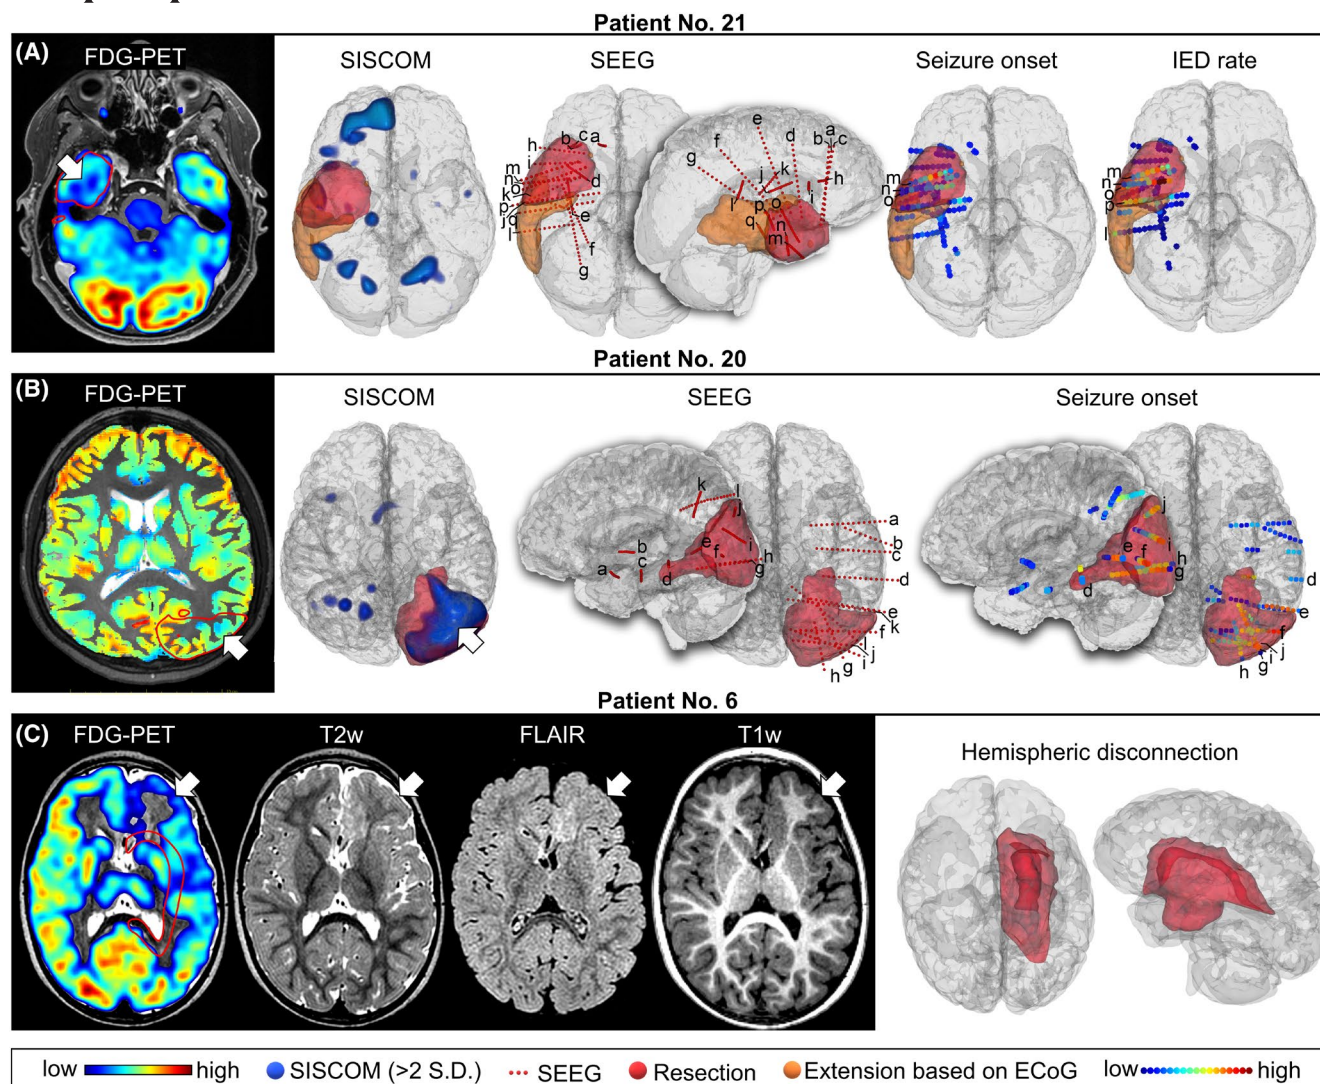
An example of the importance of multimodal assessment in three postoperative seizure-free patients. (A) Patient 21 had normal magnetic resonance imaging (MRI) findings and lateralizing but nonlocalizing single photon emission computed tomography coregistered to MRI (SISCOM). Scalp electroencephalography (EEG) showed extensive frontotemporal epileptiform activity on the right. Fluorodeoxyglucose positron emission tomography (FDG-PET) with additional postprocessing revealed a mild hypometabolism on the base of the temporal pole (arrow), which was the target of stereoelectroencephalographic (SEEG) exploration of frontal (a–c, j, k), insular (d–i), temporal (m–q) lobes, and Rolandic operculum (l). Seizure onset zones⁴¹ were confirmed in the hypometabolic tissue. However, interictal epileptiform discharges (IEDs) were widespread in the temporal lobe, indicating an extensive epileptic network⁴². The initial resection plan (red area) was extended intraoperatively on the basis of electrocorticography (ECoG; orange area) including the region uncovered by SEEG electrodes. The patient was completely seizure-free during follow-up. (B) Patient 20 had normal MRI findings with subtle hypometabolic abnormalities in FDG-PET on left parieto-occipital lobes (arrow) and multilobar left frontotemporal EEG findings. SISCOM localized the epileptogenic zone to the left temporoparieto-occipital region (arrow), which was confirmed by SEEG exploration of temporal (a–e, g), occipital (f–j), and parietal (k, l) lobes. (C) Patient 6 (an infant) had extensive left-sided structural abnormalities visible on MRI in the frontoinsular-temporal region with the corresponding FDG-PET hypometabolism (arrows). The patient underwent a left hemispherectomy. T1w, T1-weighted; FLAIR, fluid-attenuated inversion recovery.
